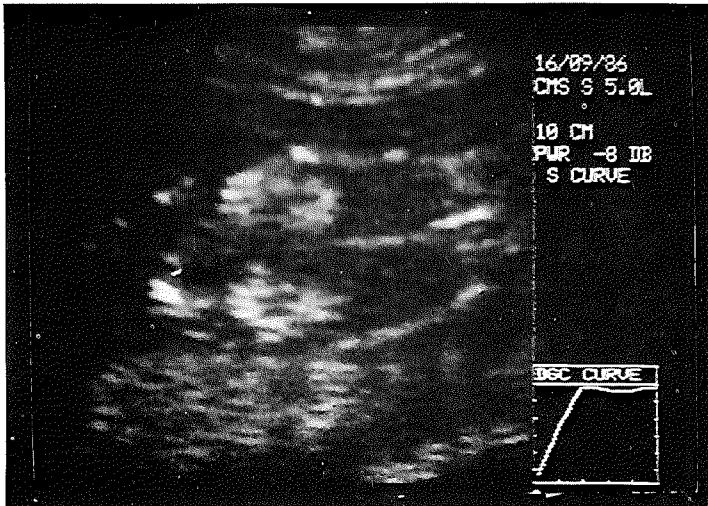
Ultrasound image of a longitudinal cross-section through the fetal abdomen. Both kidneys have a very echodense aspect.
